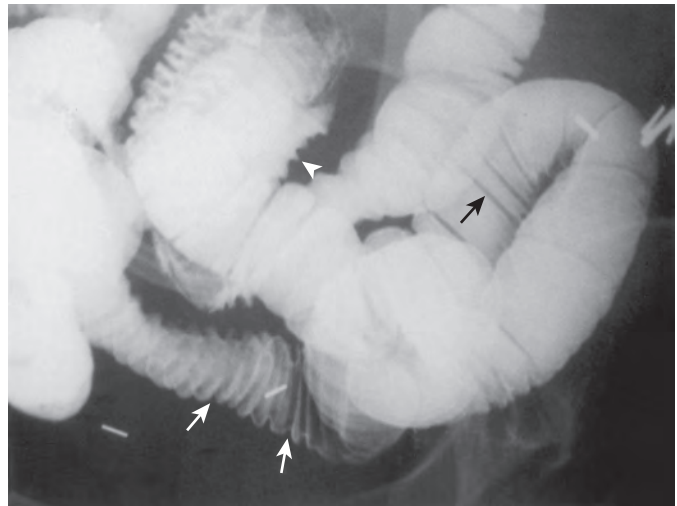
Radiation enteropathy causing low-grade small bowel obstruction. Spot radiograph from enteroclysis shows smooth, thick folds (white arrows) in a deep pelvic ileal loop. The folds are slightly angled, indicating radiation serositis. In profile, the spaces between thick loops have a spikelike appearance (arrowhead), so-called interspace spikes. A nearby loop has top normal-sized folds (black arrow) for comparison.
